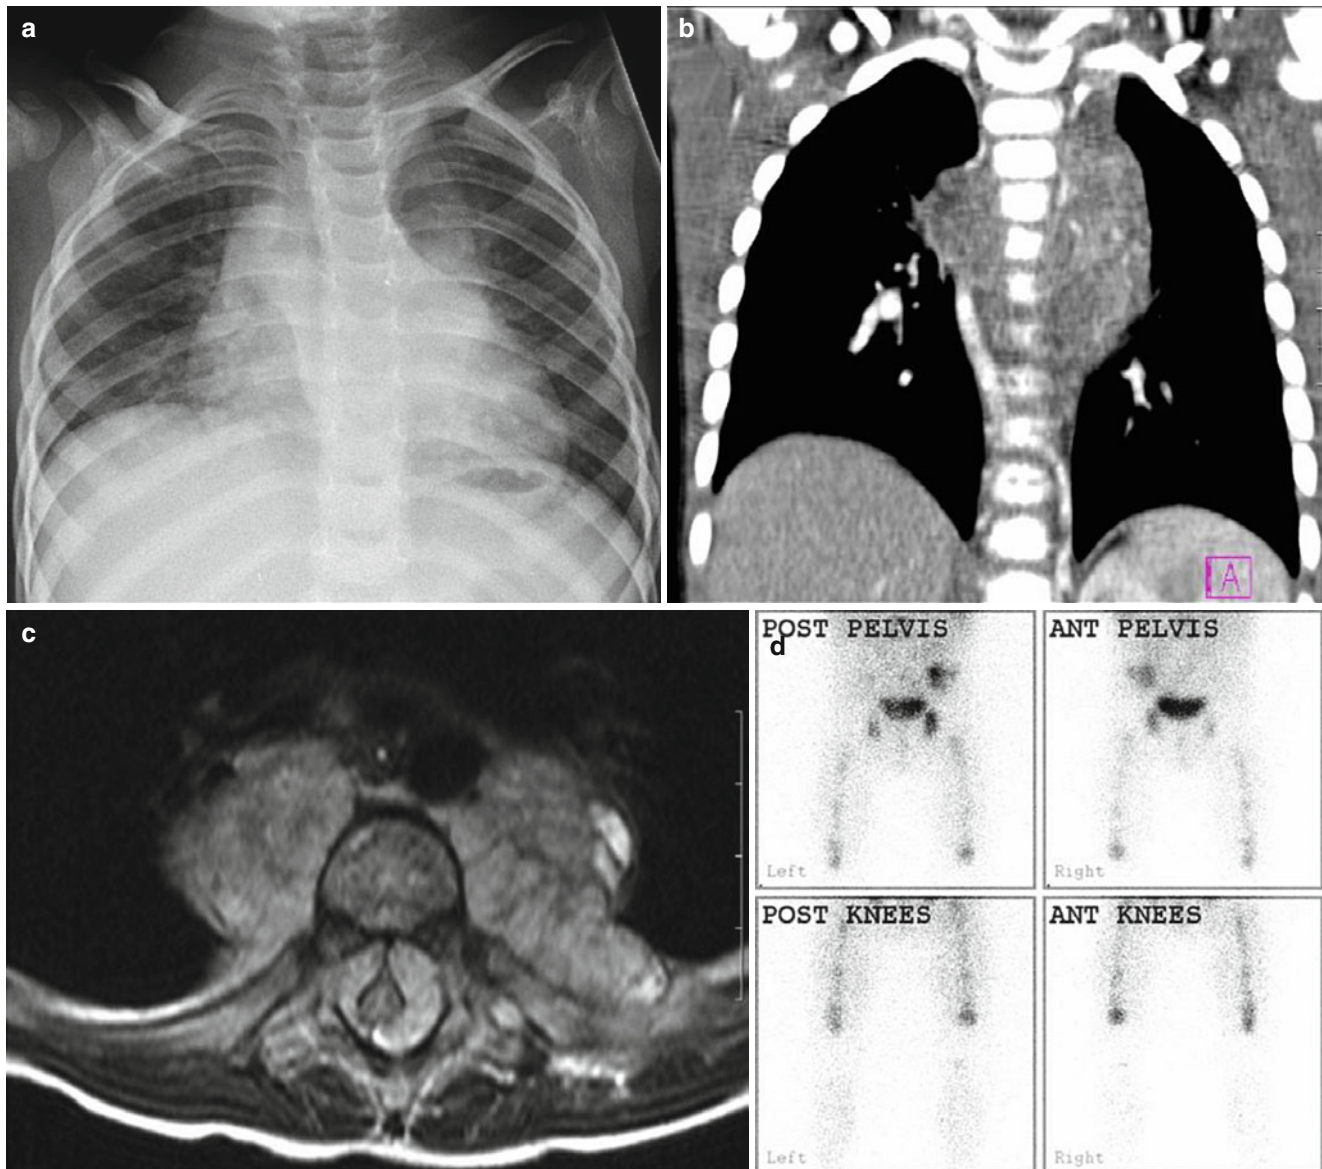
Thoracic neuroblastoma with spinal invasion and mandibular metastasis. (a) Chest radiograph showing diffuse widening of the mediastinum and increased soft tissue density in the midline. (b) CT with contrast in a coronal reconstruction with tumor seen both sides of the thoracic spine. (c) MR of the spine showing tumor invasion into the spinal canal bilaterally forming a horseshoe of tissue around the spinal
